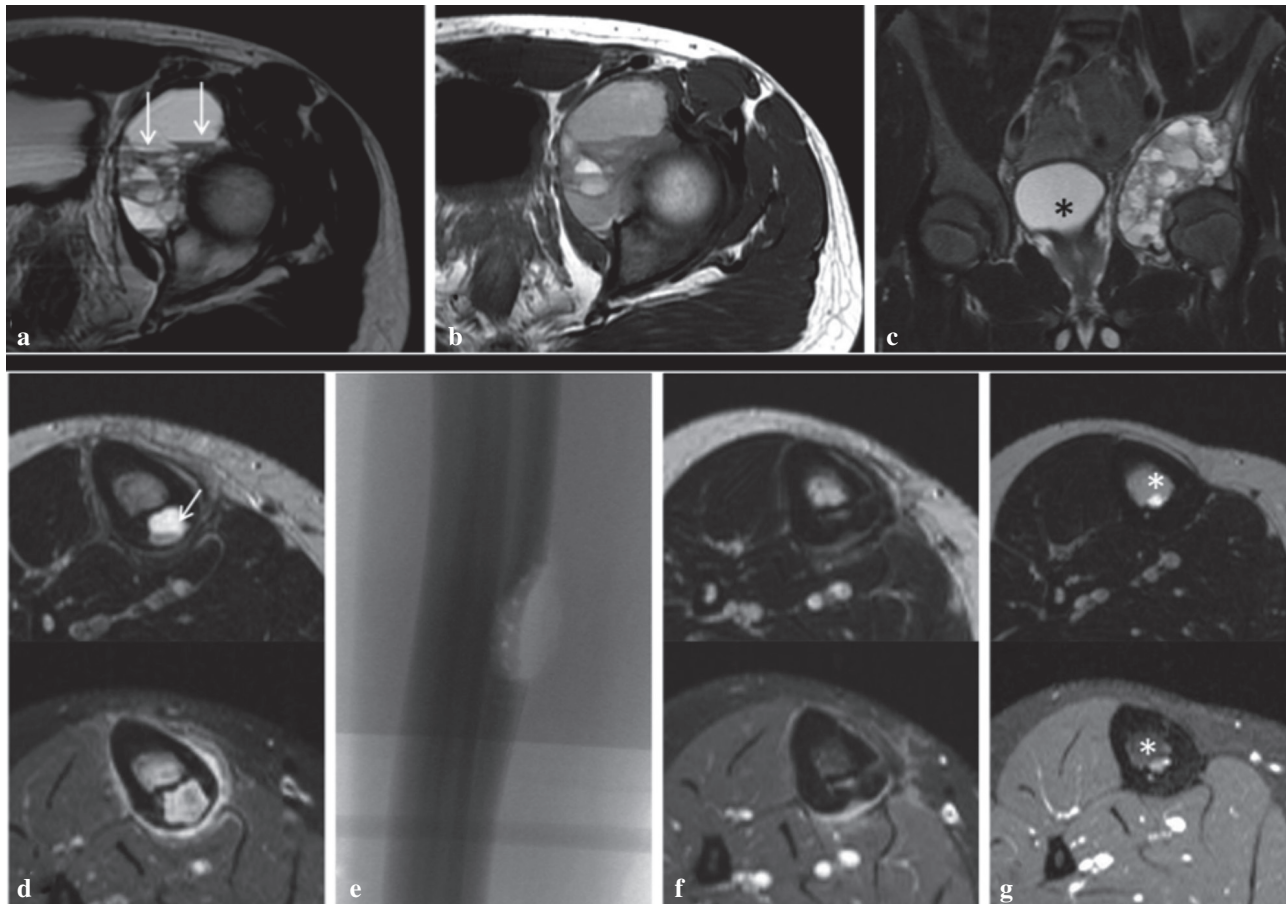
(a-c). — Typical MR appearance of aneurysmal bone cyst. (a) T2-weighted axial turbo spin echo sequence shows an expansile cystic mass in the left acetabular region with distinct fluid-fluid levels (→). (b) T1-weighted axial turbo spin echo sequence confirms high protein levels within cystic fluid compatible with hemorrhagic changes. (c) Coronal STIR image shows craniocaudal extension of the multiseptated lesion to the hip joint and pelvic cavity with slight displacement of the bladder (*). (d-g) Treatment and follow-up of an eccentric, diaphyseal aneurysmal bone cyst (ABC) of the right tibia. (d) Small ABC with typical fluid-fluid-level (→) on axial T2-weighted (top) and contrast-enhanced T1-weighted (bottom) MR images. (e) Intraoperative fluoroscopy image after curettage of the lesion. (f) MR follow-up 3 months after treatment shows only slight enhancement of granulation tissue and confirms complete removal of the ABC. (g) 12 months after treatment, however, a de novo cystic lesion (*) with contrast enhancement can be appreciated at the endosteal margin of the resection site, indicative of recurrent ABC.
